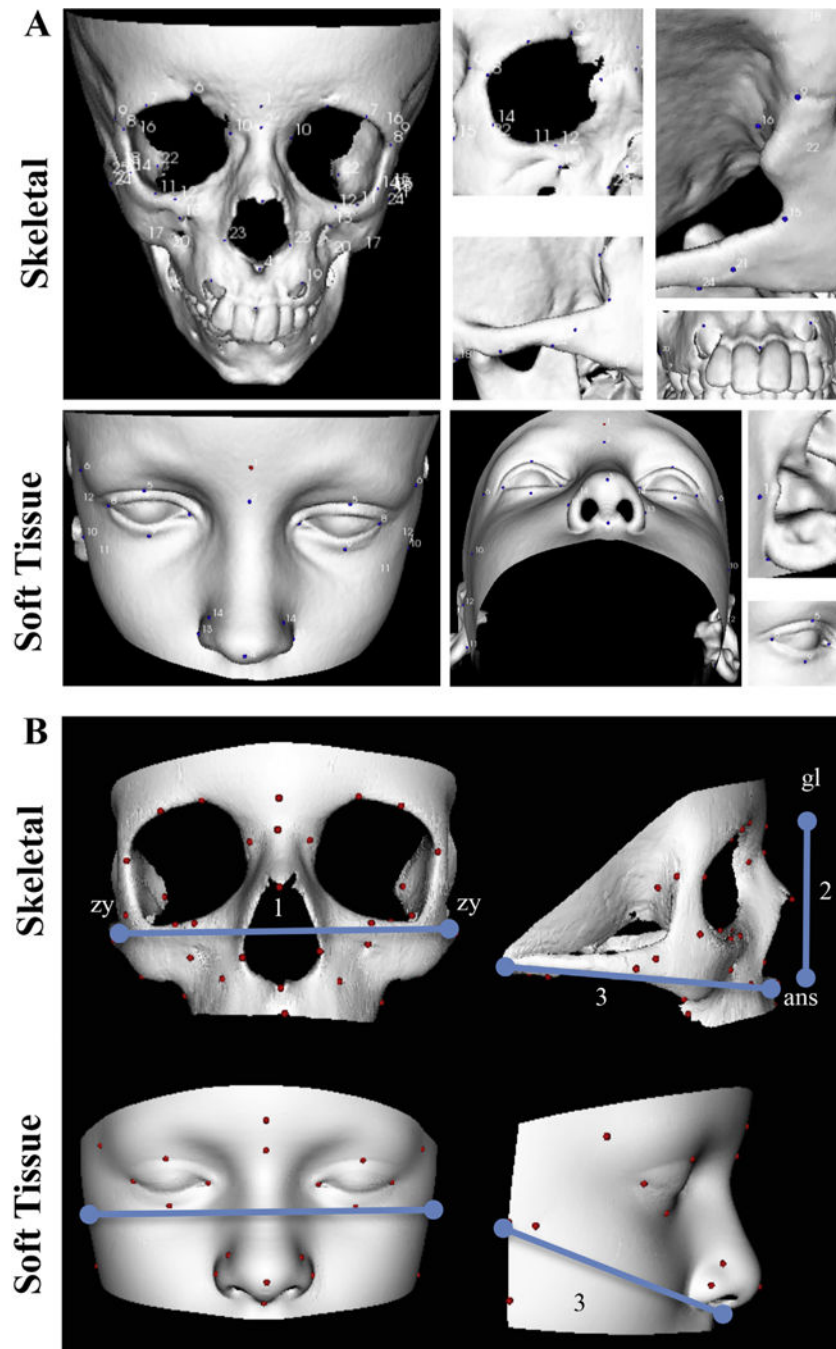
Skeletal and soft tissue 3D reconstructed CT scans annotation. A) Skeletal and soft tissue 3D reconstructions annotated with landmarks described in Table 1. B) Landmarking for cephalometric measurements. 1: width (zy-zy). 2: length (skeletal: gl-ans; soft tissue: gl-sn). 3: depth (skeletal: ans-m; soft tissue: sn-p); *ans*: anterior nasal spine, *gl*: glabella, *m*: mastoidale, *na*: nasion, *p*: preaurale, *sn*: subnasale, *zy*: zygion.
